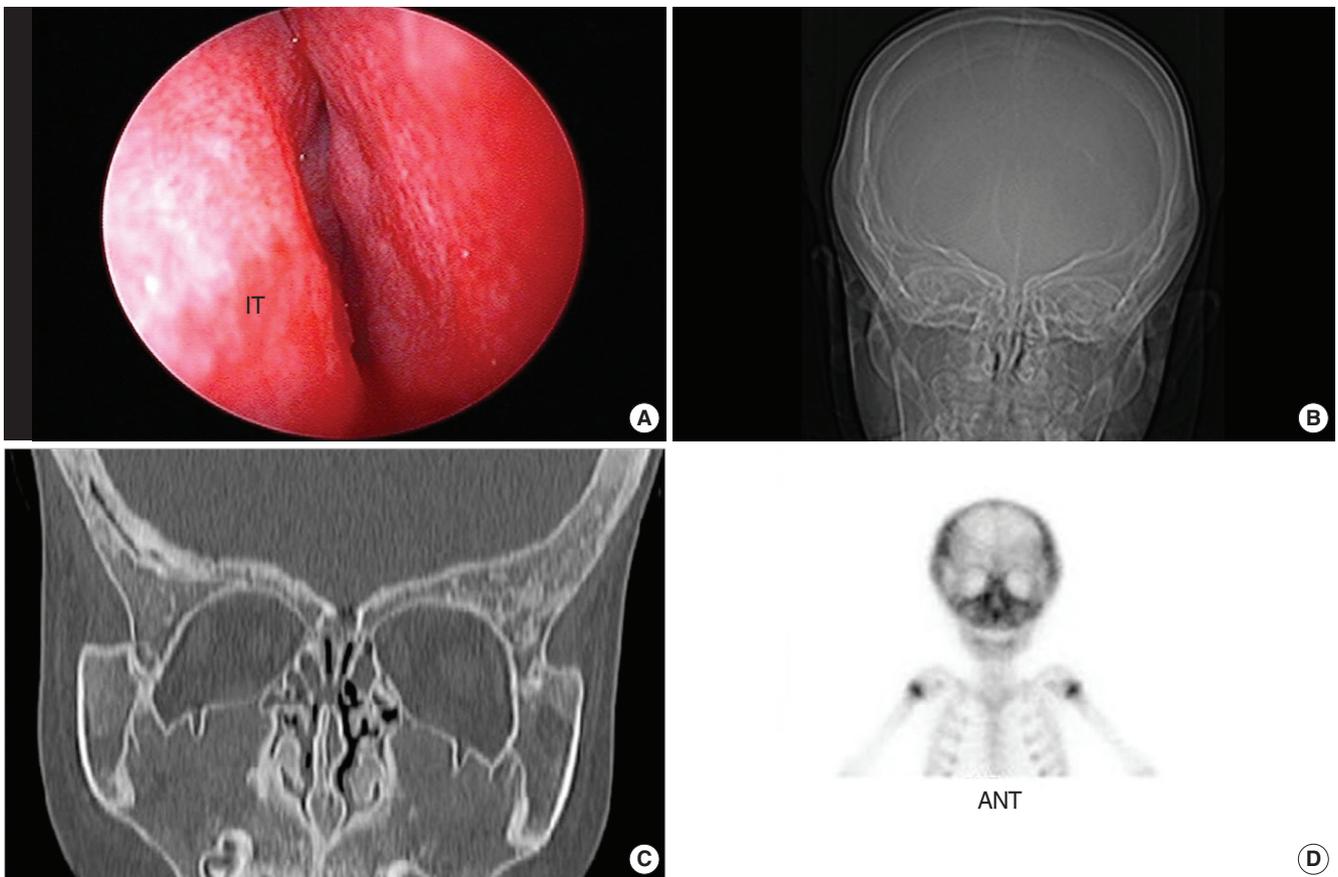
(A) Endoscopic view showing hypertrophic change of inferior turbinate & nasal cavity narrowing of right side. (B) Plain radiography showing thickening and sclerotic changes in the facial bone and skull vault, and unformed obliterate paranasal sinuses. (C) Coronal computed tomogram revealing complete agenesis of both paranasal sinuses but not the ethmoid sinuses. (D) Bone scan showing marked uptake of radionuclide in both paranasal sinuses, especially the maxillary sinuses. IT: inferior turbinate.
